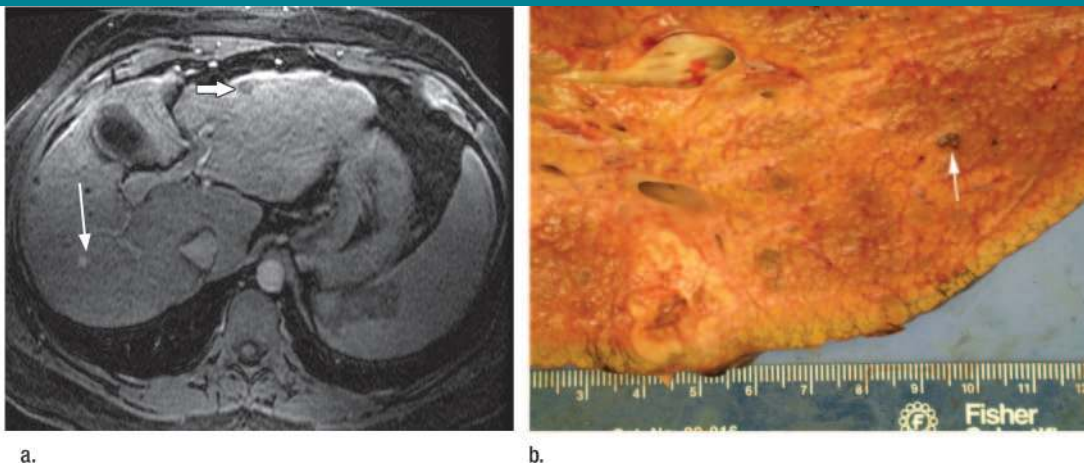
Images in 46-year-old man with hepatitis C-related cirrhosis. (a) Arterial-dominant phase transverse T1-weighted three-dimensional SPGR MR image (3.6/1.7, 12° flip angle) shows a 6-mm nonspecific hypervascular lesion (thin arrow). This patient has a dominant 5-cm HCC (not shown). A small nodule in the anterior lateral segment of the left lobe (thick arrow) was found to be a cirrhotic nodule. (b) At explant evaluation, the tiny hypervascular lesion was found to be a hemangioma (arrow).
